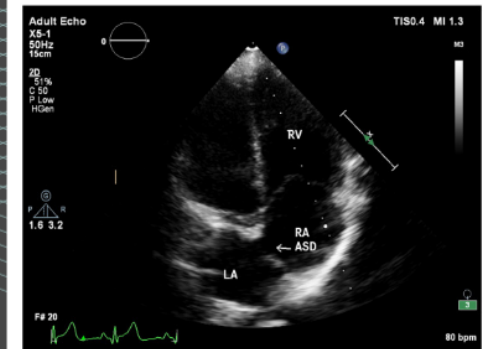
Trans-thoracic echocardiography showing a 14mm defect between the right and left atrium. Not of our current patient. Taken from reference (3)
